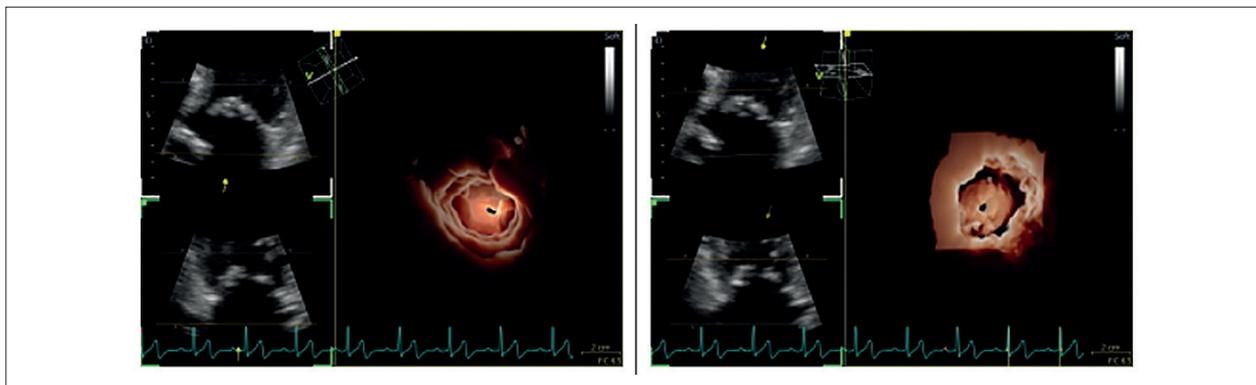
Three-dimensional transthoracic echocardiography of the mitral valve in severe rheumatic mitral stenosis with tunneling. On the left, atrial view with the tunneled valve orifice, typical of severe rheumatic anatomies. On the right, ventricular view showing the elongated, narrow trajectory of the functional orifice, with commissural fusion and associated subvalvular restriction.
